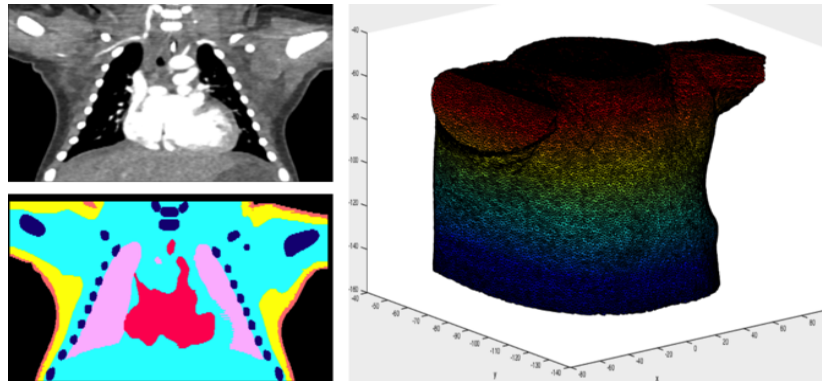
Figures on the left show the comparison between the raw CT image and the finished segmentation of different tissues labeled by different colors. The pink color indicates the lung, the red for the heart, the yellow for the fat, the orange for the skin, the light blue for the muscle and the deep blue for the bone. Figure on the right shows the created mesh.
